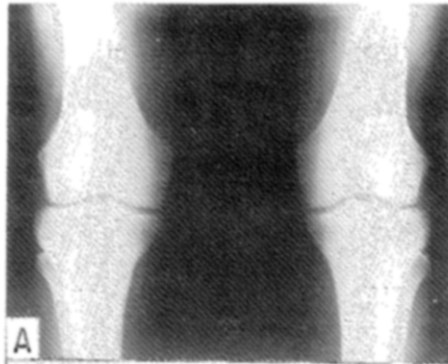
Normal synovial membrane scans 6 hr after i.v. administration of ^{113}In -HSA. Roentgenograms of knees (A) show area scanned from anterior aspect (B). Lateral roentgenograms (C) show area scanned from medial aspect of knee (D). Roentgenograms of hands (E) show area scanned (F). Note that only normal vascularity is shown. Synovial membrane areas are not identified.
